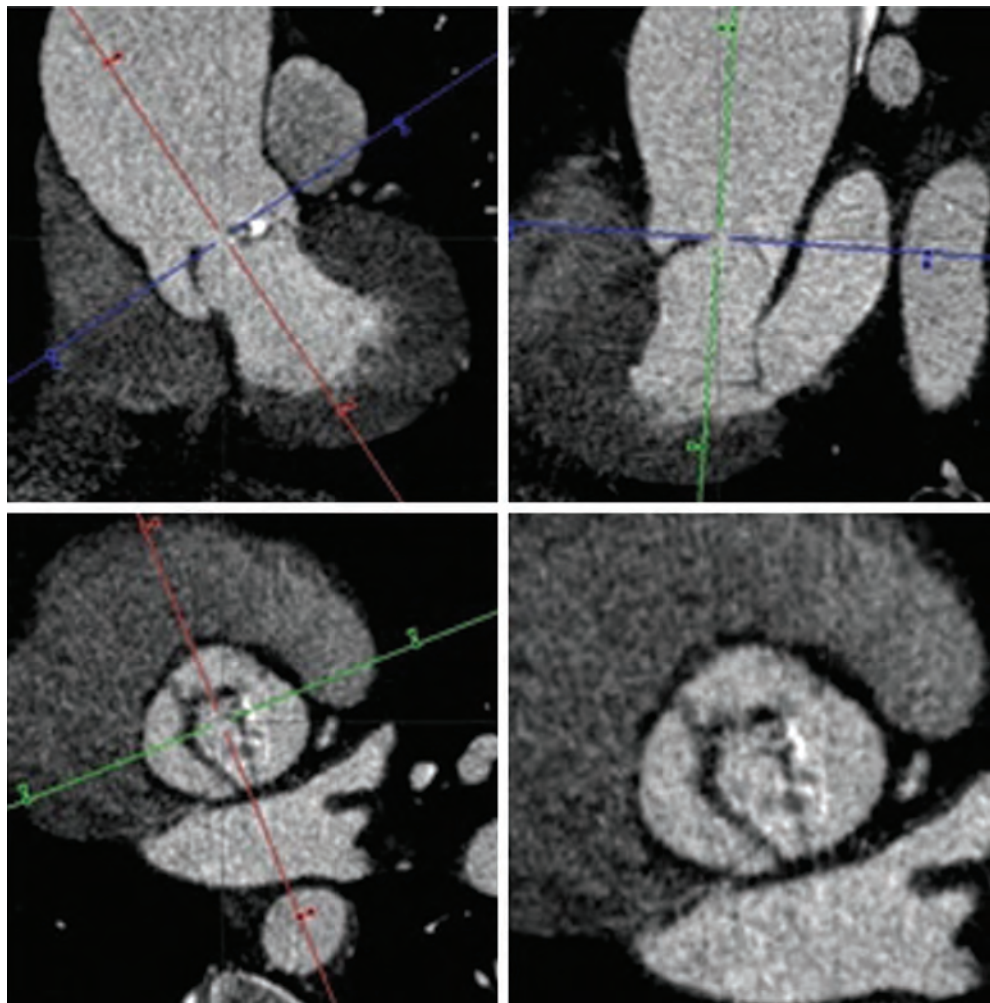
Computed tomographic angiography. (A and B) Orthogonal radiographs display the ascending aortic aneurysm. (C and D) The bicuspid aortic valve (BAV) in short-axis view for evaluation of the valve area by planimetry.
